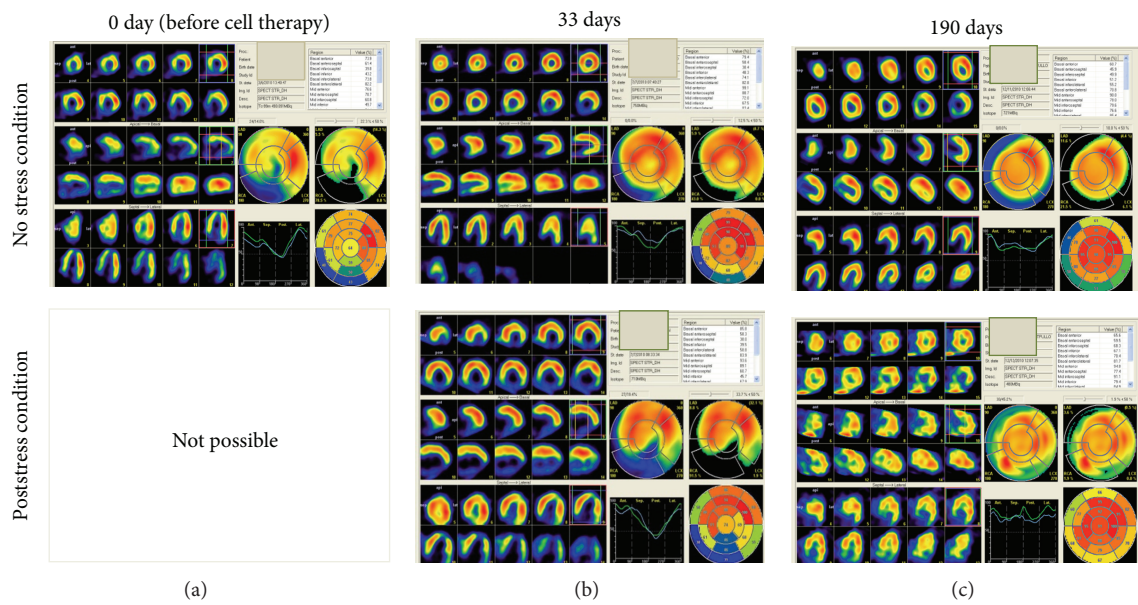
Kinetic of the areas that benefit from myocardial revitalization after cell therapy carried out by myocardial scintigraphy before and after 33 and 190 days. The strong uptake of Tc99 isotope in the inferoseptal region of the heart in poststress condition showed by arrow. (black, no perfusion; blue-green-yellow-red, increasing perfusion).
